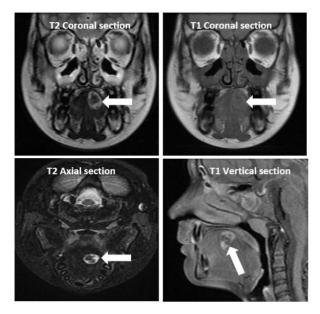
Left sided lesion visualized on MRI sections
